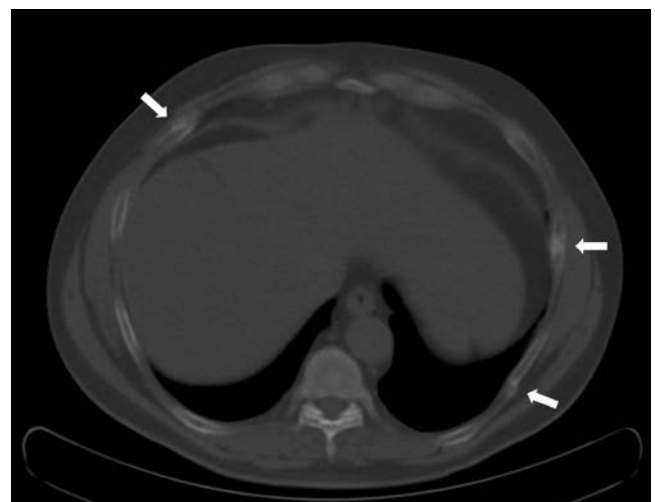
Axial computed tomography image of the lower chest showing several healing fractures of the rib with callus formation (arrows).
